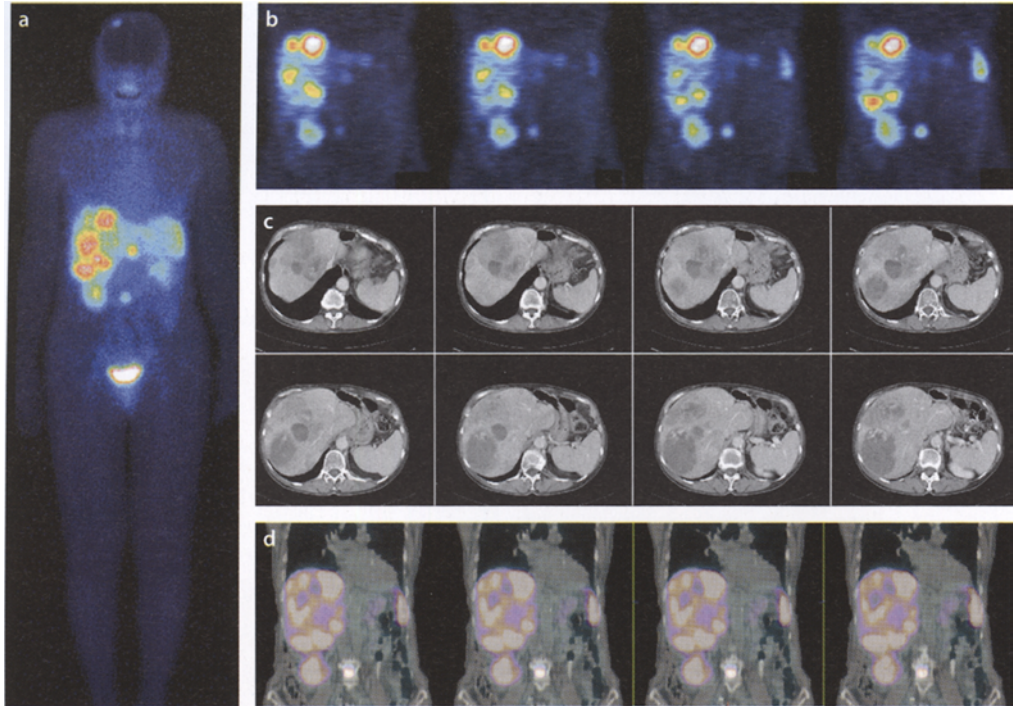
^{99m}Tc EDDA Hynic TOC whole-body scan: (a anterior view 1 h postinjection) and SPECT slices (b coronal view 2 h p.i.) demonstrating multiple liver metastases of a bronchus carcinoid operated 17 years before. In addition, bone metastases in the lumbar spine and in the skull are seen. c and d show the transaxial CT and coronal PET slices of the same patient using Ga-68 DOTA-NOC with intense accumulation of the somatostatin analog in the liver metastases
